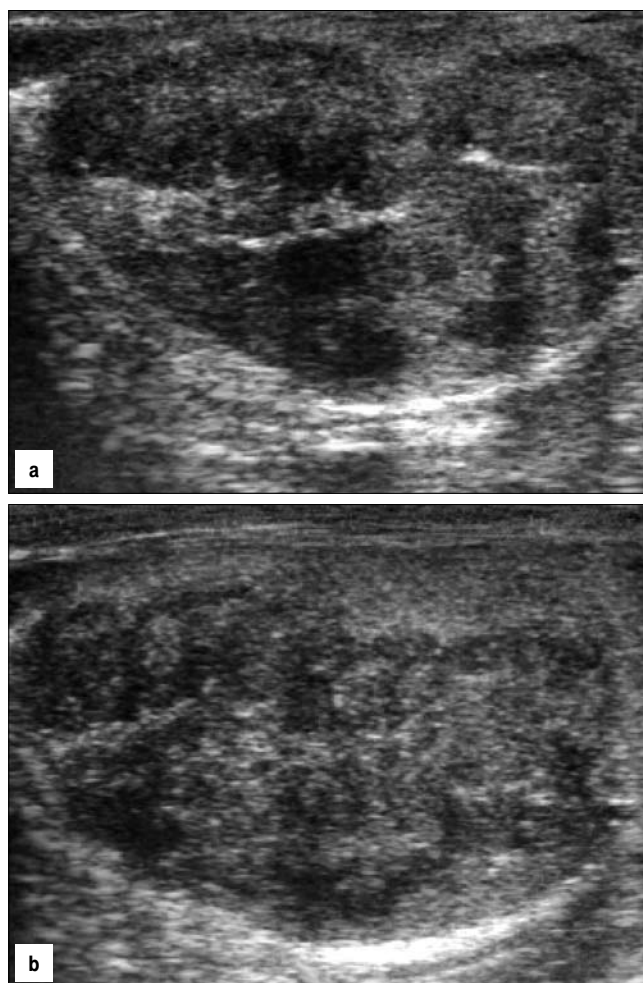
Bilateral testicular adrenal rest tumors shown by ultrasound: 1a – right testis, 1b – left testis.
